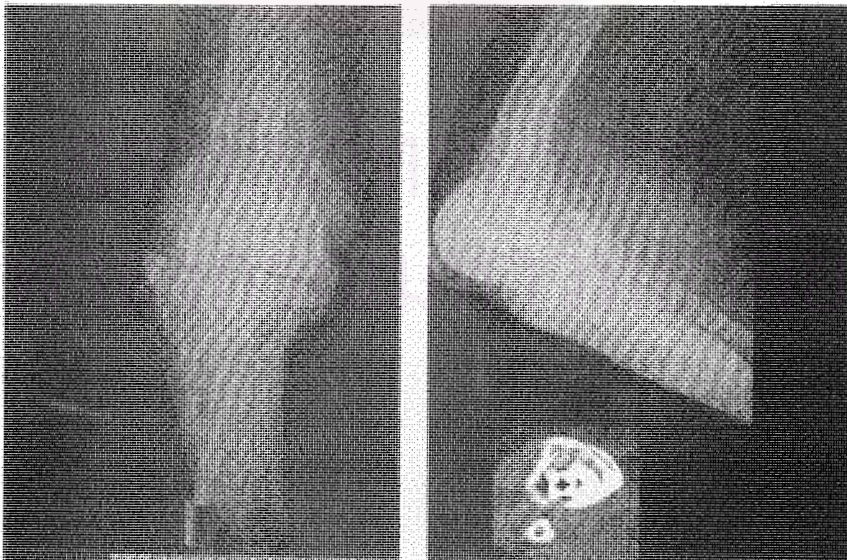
Preoperative radiographs of the right knee of the first patient and the CT images. The loosening hinged prosthesis causes varus deformity of the knee with massive tibial bone loss. The distal stem of the tibial component penetrates through out the tibial cortex.
